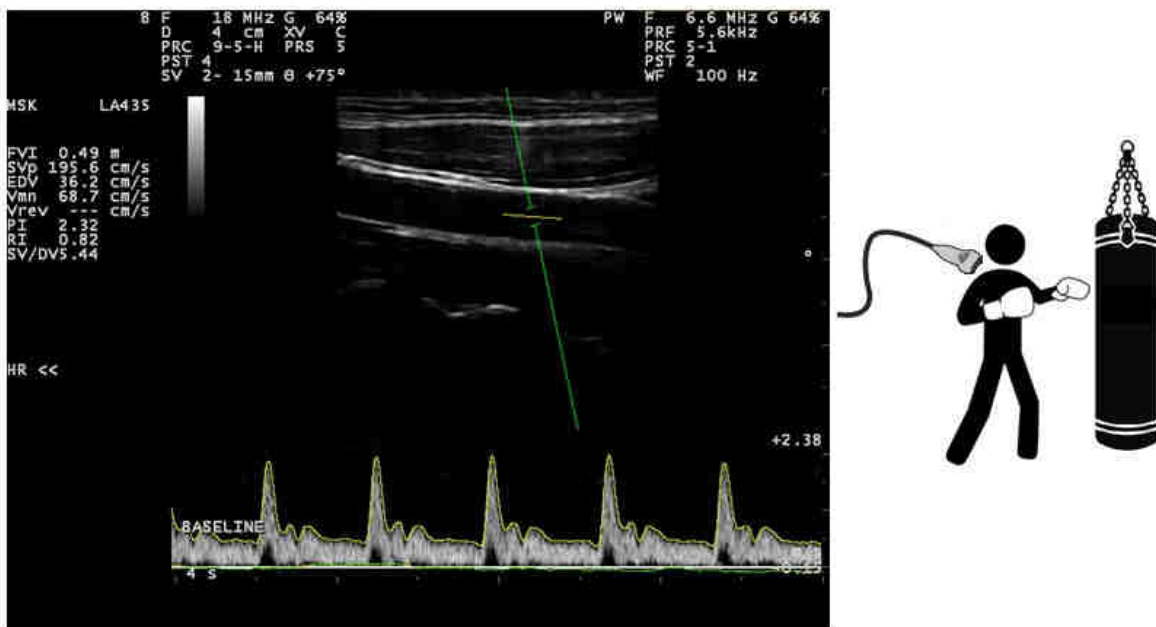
Doppler-ultrasound of the common carotid artery during heavy bag punching.
